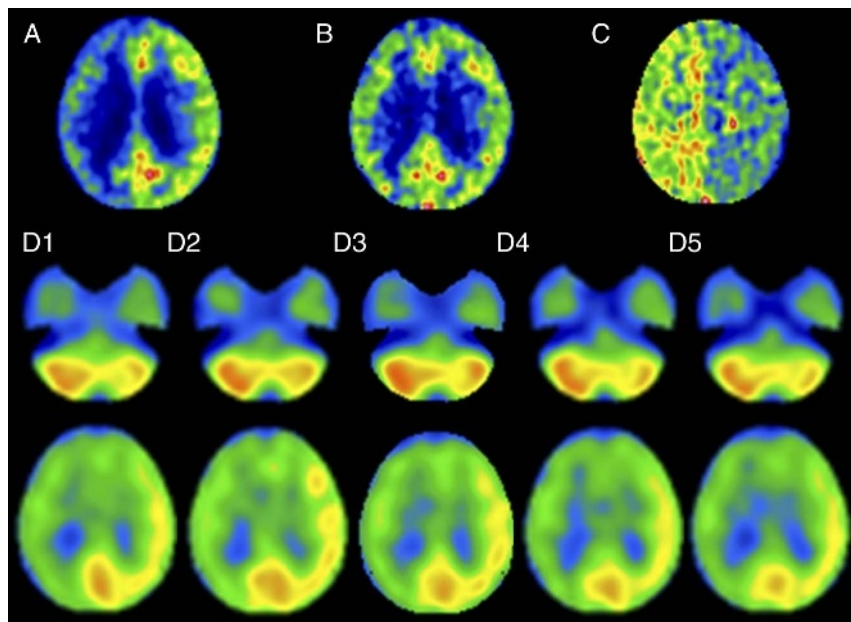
A 66-year-old man with symptomatic occlusion of the right ICA. Upper images, ^{15}O gas PET images including CBF (A), CMRO_2 (B), and OEF (C). Although CBF is lower in the right cerebral hemisphere than in the left cerebral hemisphere, the degree of asymmetry in CMRO_2 is less, resulting in considerably greater OEF in the right cerebral hemisphere than in the left cerebral hemisphere. D1 to D5, $^{99\text{m}}\text{Tc}$ -ECD SPECT images at 0 to 10 minutes, 10 to 20 minutes, 20 to 30 minutes, 30 to 40 minutes, and 40 to 50 minutes (D1–D5) after tracer administration. Tracer uptake is lower in the right cerebral hemisphere than in the left cerebral hemisphere and in the left cerebellar hemisphere than in the right cerebellar hemisphere at all scan times after tracer administration. The degree of the asymmetry appears to be greater on images with a scan time of 10 to 20 minutes and 20 to 30 minutes after tracer administration than with other scan times.
